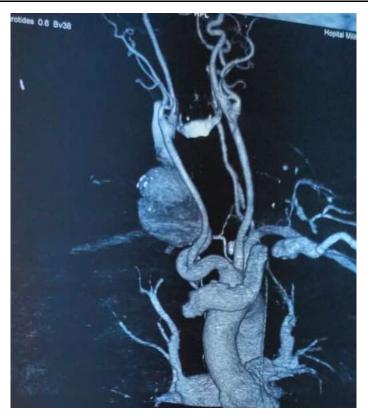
Computed tomographic angiography showing a false aneurysm of the right subclavian artery.
